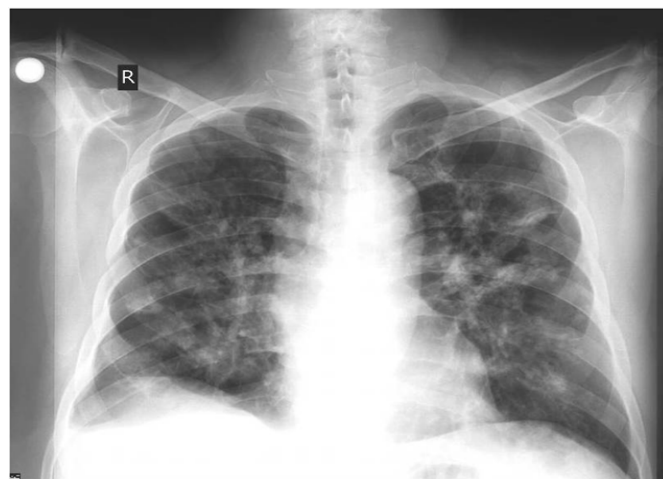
The chest X-ray on admission demonstrated ill-defined parenchymal opacities in the peripheral areas of both lungs
